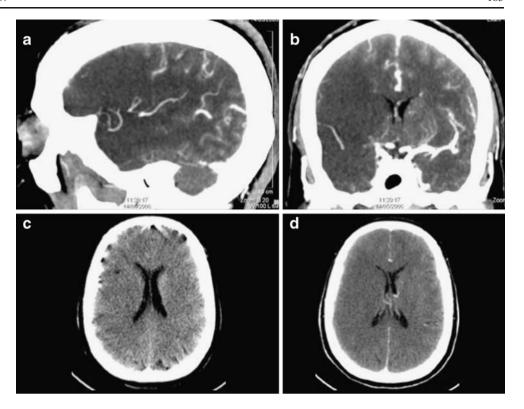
Patient with signs of right hemispheric stroke. The thick reconstructions of the CTA show the compromised better visualized (a, b) than the axial unenhanced slices (c, d)
